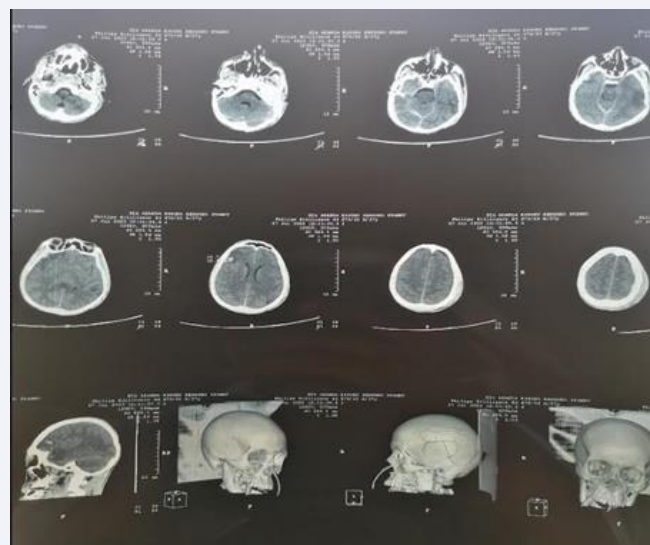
CT scan at J7 follow up
